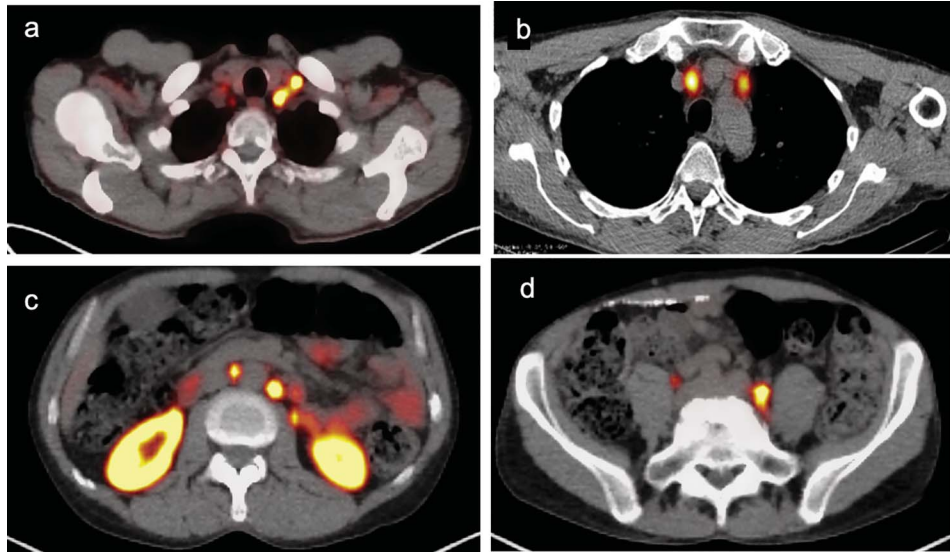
Lymph node metastases. ^{68}Ga -PSMA PET/CT scan obtained for recurrent PCa in a 68-year-old patient with PSA of 24 ng/ml 6 years following radiation therapy for Gleason score 4+4=8 PCa. Note visualization of lymph node metastases in left supraclavicular region (a), mediastinum (b), retroperitoneum (c) and pelvis (d). Radiotracers, which bind to the extracellular epitope of PSMA, allow detection of PCa at various sites throughout the body; lymph node involvement by PCa was often undetectable prior to the advent of PSMA scanning. Uptake of ^{68}Ga in the kidneys (shown here) is physiological.
